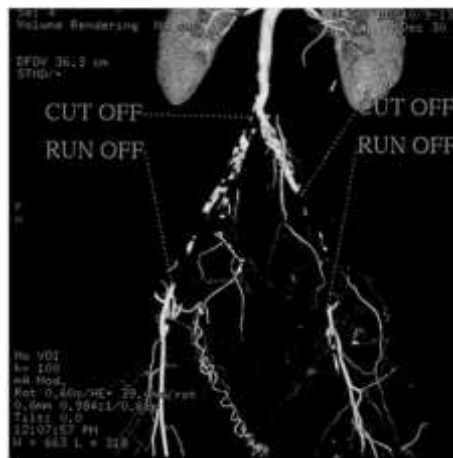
CT Angiography showing Cut off and Distal Run Offs
